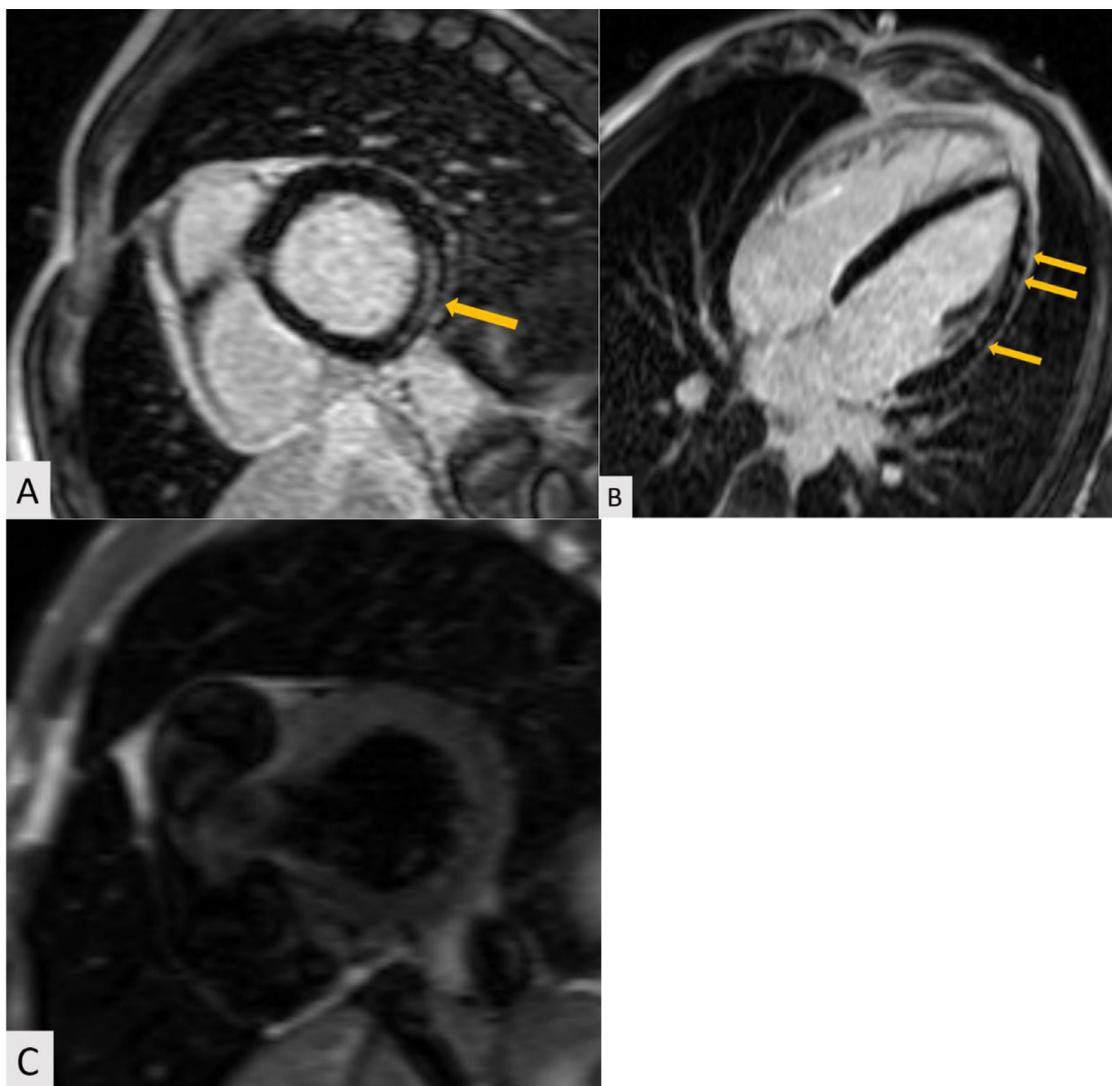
(A) Short axis and (B) 4-chamber late gadolinium enhancement MRI nine months following COVID-19 infection in a 34-year-old patient demonstrates multifocal subepicardial and mesocardial enhancement, predominantly involving the lateral LV wall (arrows), consistent with chronic COVID-induced myocarditis; (C) Note the lack of myocardial edema on short axis T2 imaging, indicating chronicity.
